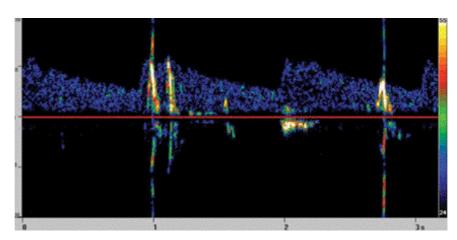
Asymptomatic cerebral microemboli detected as high intensity transient Doppler signals downstream from symptomatic high grade internal carotid artery stenosis.
